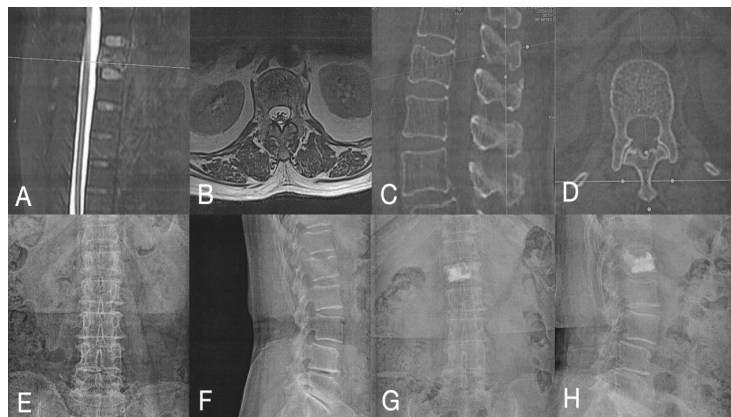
A, B) Female patient, 61 years old, preoperative lumbar MRI showing bone marrow edema at L1. C, D) Preoperative CT showing discontinuity in L1 vertebra; E, F) Preoperative lumbar X-rays (frontal and lateral) showing compression of the anterior and middle columns of the L1 vertebra; G, H) Unilateral transpedicular approach with C-arm oblique view assisting balloon kyphoplasty, postoperative lumbar X-rays (frontal and lateral) showing good cement distribution and restored vertebral height.
